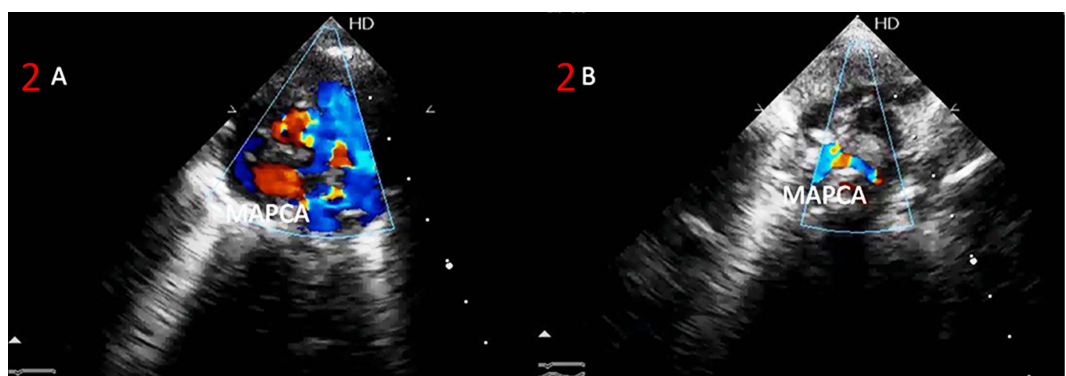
(A) Parasternal short axis and (B) suprasternal view demonstrating major aortopulmonary collateral arteries.
